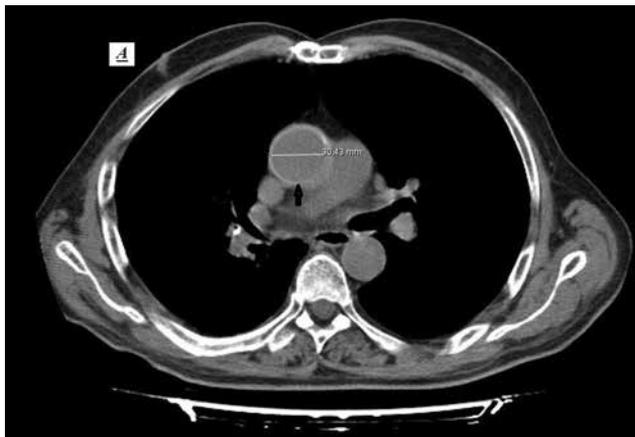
Postoperative computed tomography scan demonstrates of wrapping.
